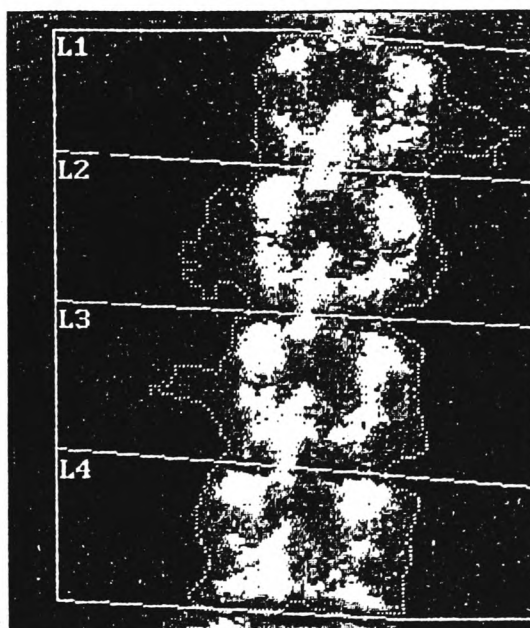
Scans of patient with calcification of the soft tissue taken with interval of 1 year. The first scan shows less influence of the calcification than the second scan where L1, L2 and L3 are clearly affected. This patient was subsequently x-rayed and was found to have calcification of the overlying psoas muscle.
